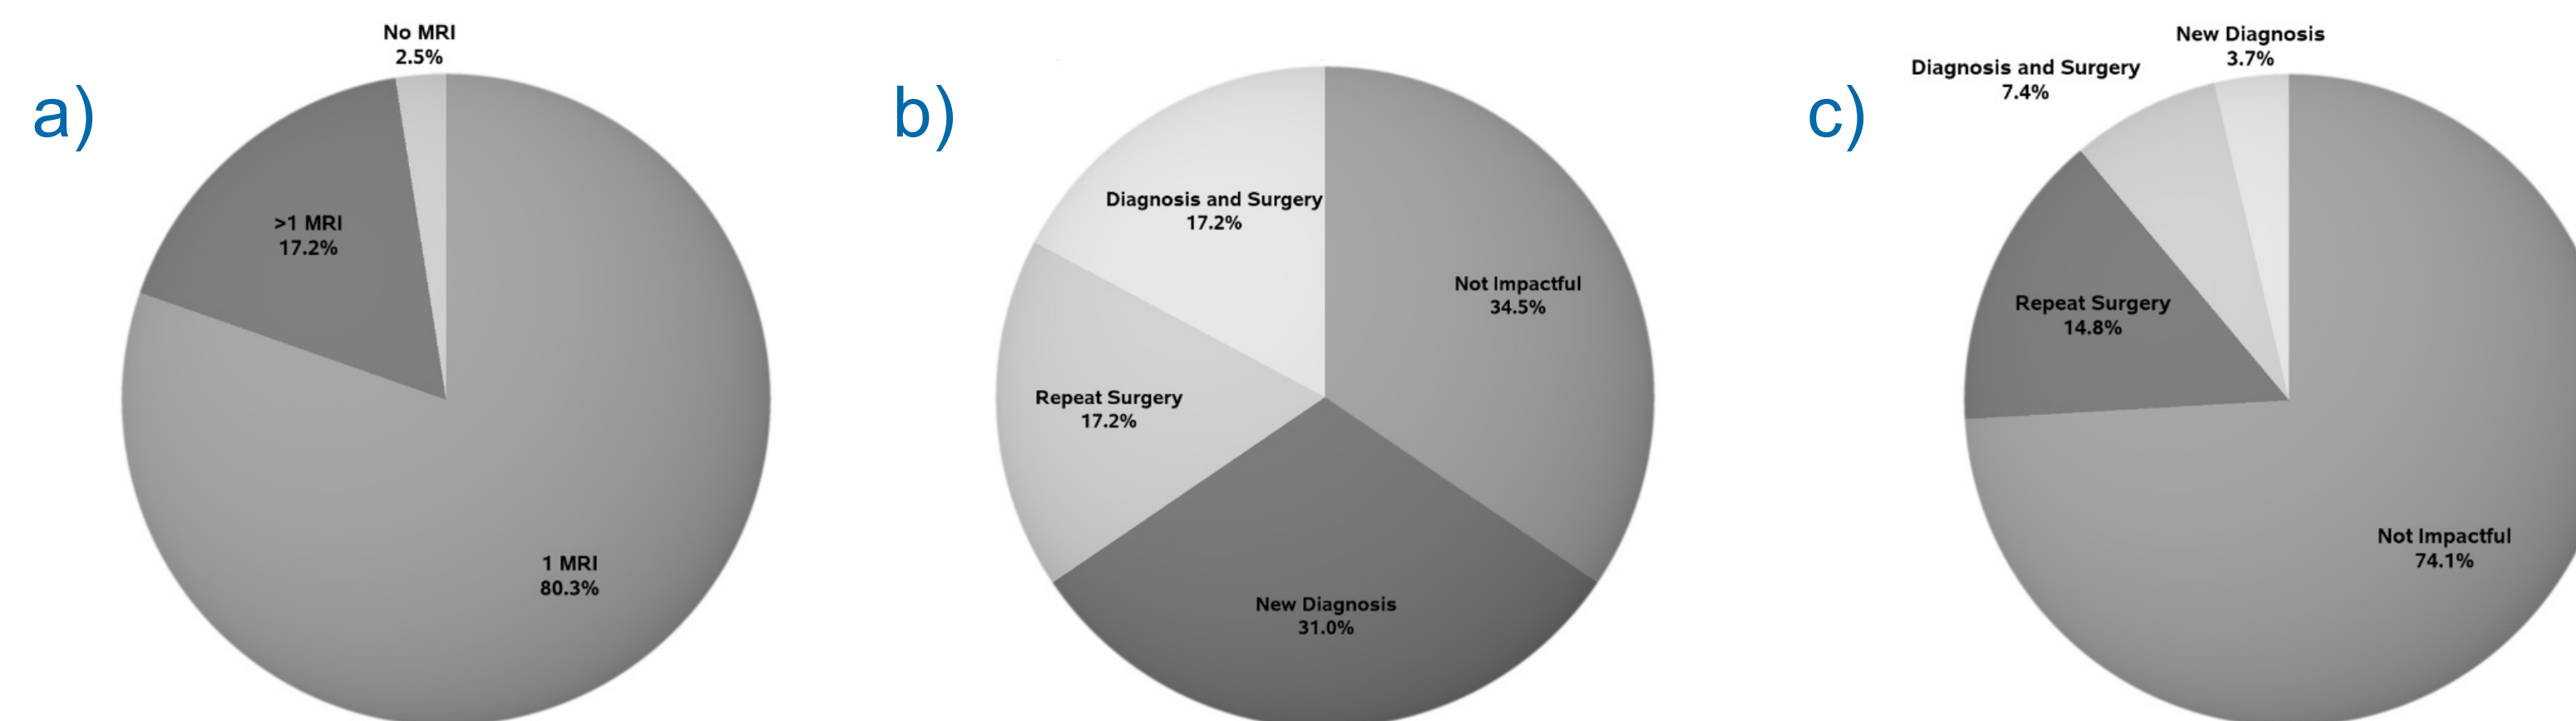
Figure Legend: (A) Proportion of included patients undergoing no MRIs, 1 MRI, and more than 1 MRI during clinical care (including both inpatient and outpatient studies from 3 weeks prior to admission until 24 months after discharge); Clinical impact of repeat MRIs performed while inpatient during course of initial hospitalization (B) or outpatient after hospital discharge (C) including no impact to care, identification of a new diagnosis, repeat surgical procedure within 24 hours of MRI, or both new diagnosis and repeat surgery.
